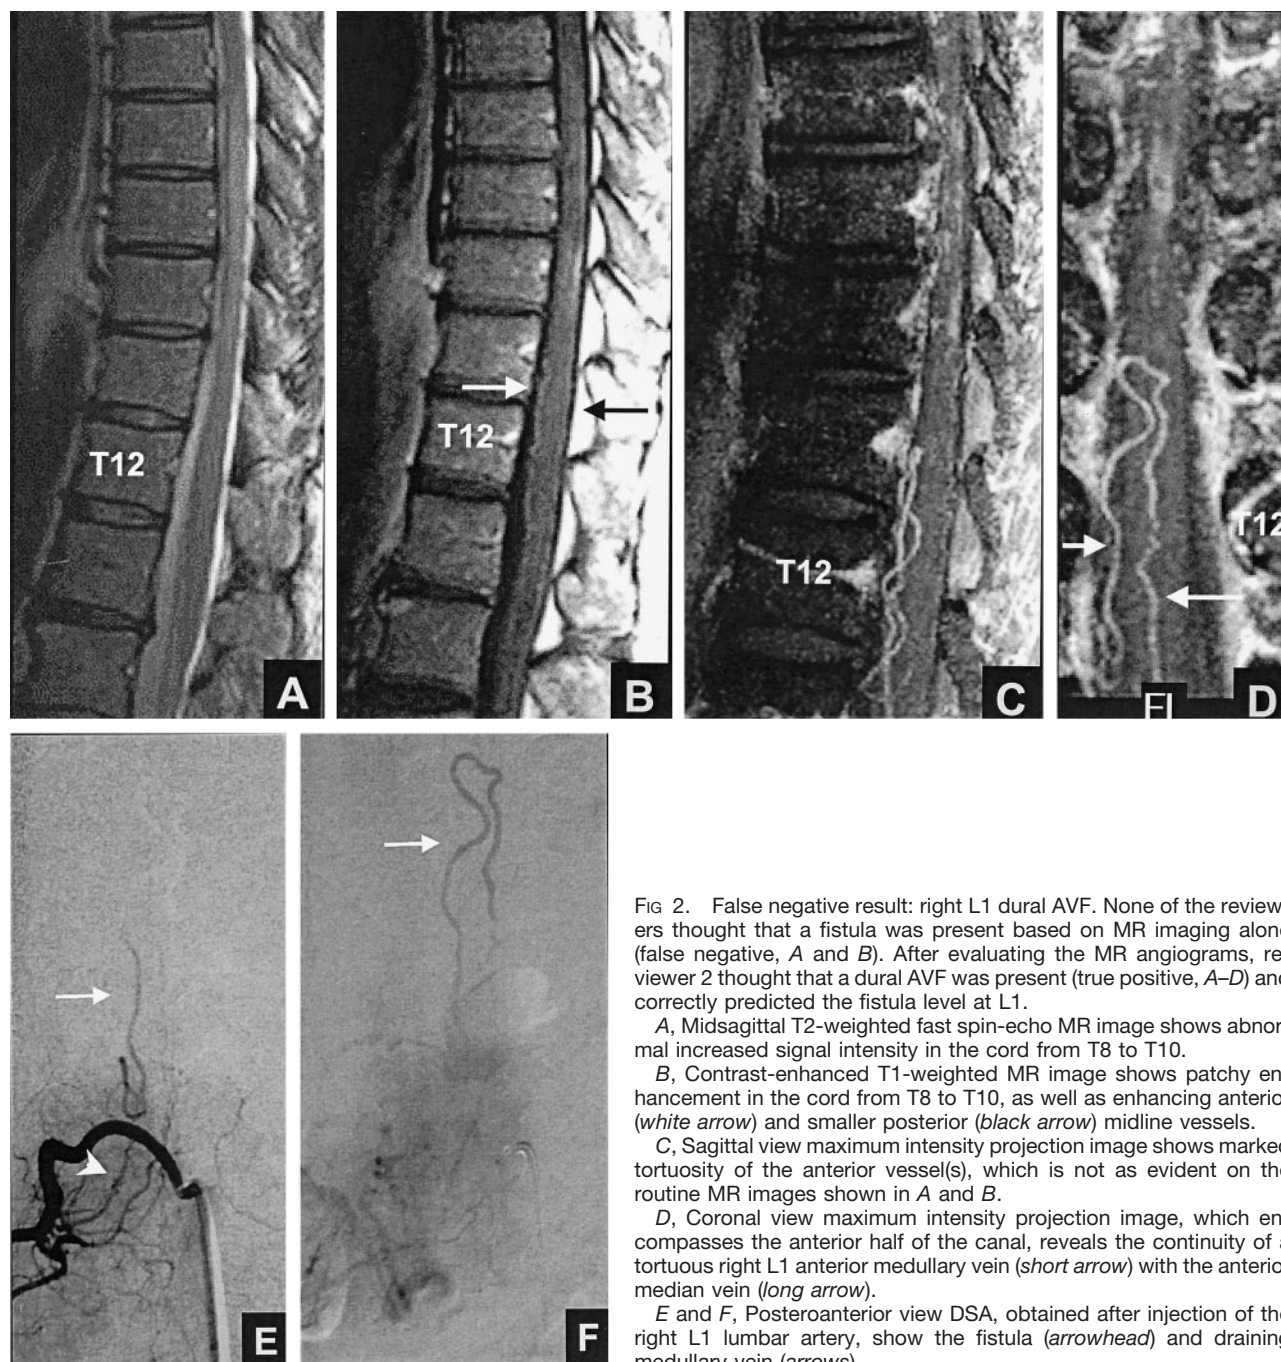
False negative result: right L1 dural AVF. None of the reviewers thought that a fistula was present based on MR imaging alone (false negative, A and B). After evaluating the MR angiograms, reviewer 2 thought that a dural AVF was present (true positive, A–D) and correctly predicted the fistula level at L1.
